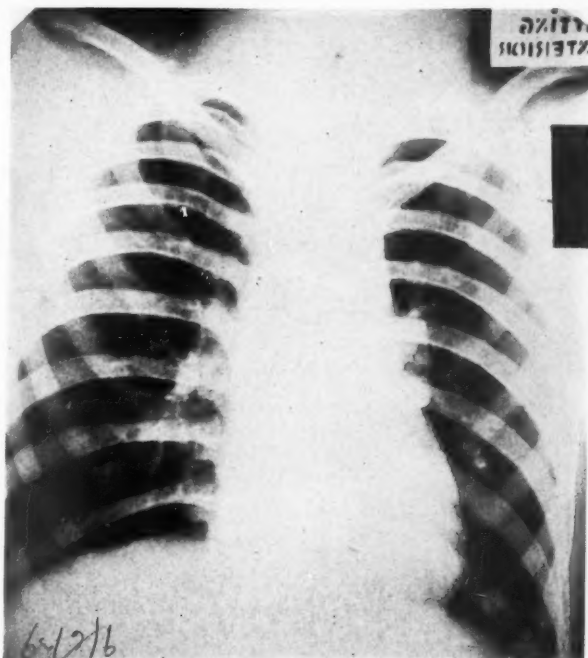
Roentgenogram of chest, showing absence of aortic knob and broadening of the aortic arch.
